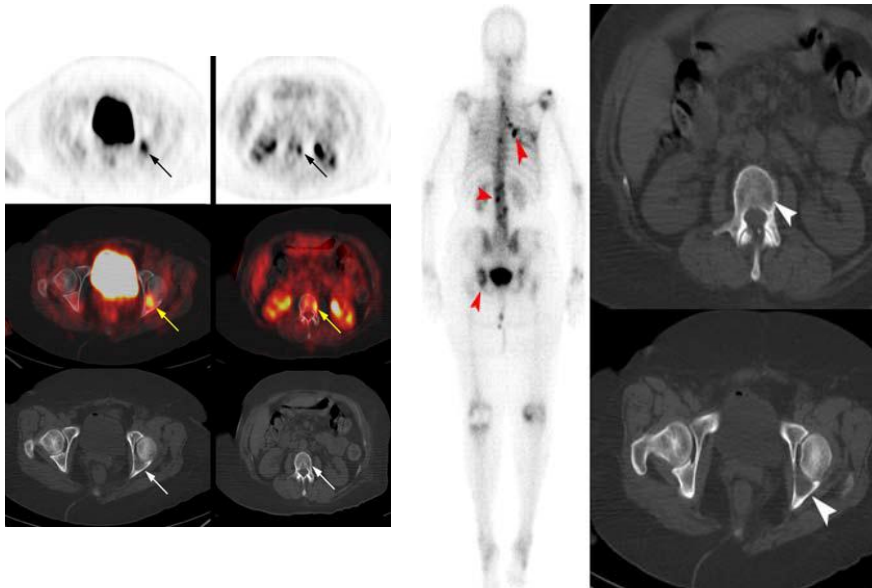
shows Discordant PET/CT findings (true-positive at PET, false-negative at CT) in 72 year old woman referred for lung cancer staging. (A) Transverse PET (top), PET/CT (middle), and CT (bottom) scans show acetabular and spinal metastases identified with PET (black and yellow arrows) that were initially interpreted as negative with CT (white arrows). (B) Follow up bone scan (left) and CT scans (right) obtained 6 weeks later. Posterior planar bone scan helps confirm multiple metastatic foci in the ribs, spine, and pelvis (red arrowheads). Transverse CT scans help confirm lytic metastases in the spine and acetabulum (white arrowheads) ⁽¹⁰⁾.
